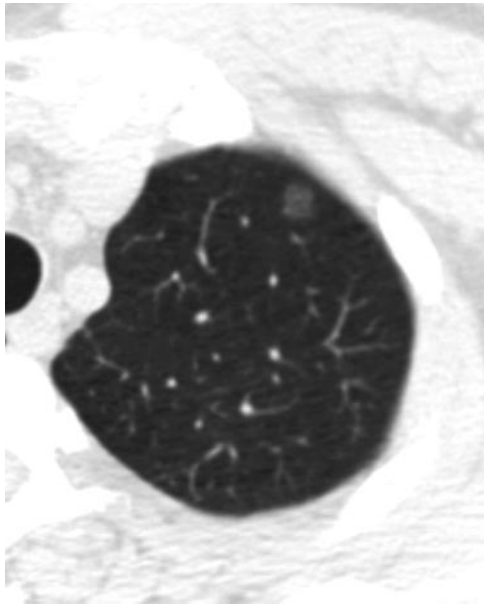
AAH in a 64-year-old asymptomatic woman with previous thyroid cancer. Transverse thin-section CT scan shows a 7-mm GGO nodule without an internal solid part in the left upper lobe.
